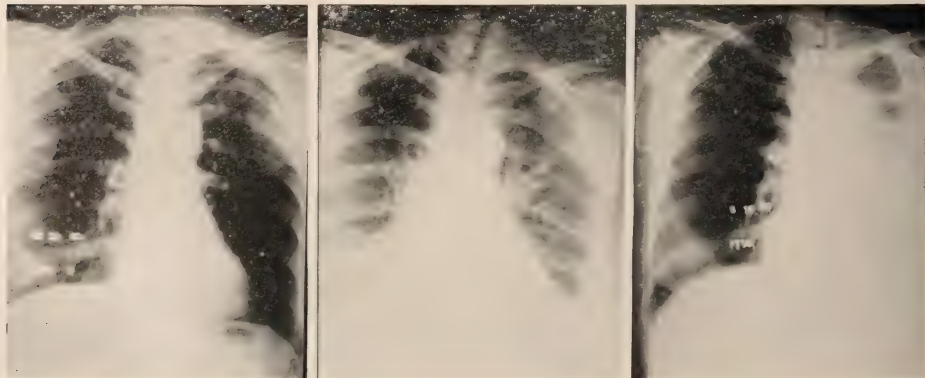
Case No. 15010—Mrs. J. W.—(1) Roentgenogram made at time of admission, showing no increase in density in the left lung. (2) Showing beginning increase in density in the central portion of the left
